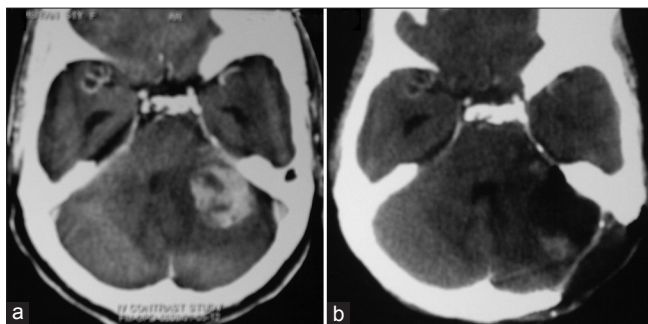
Contrast computed tomographic scan of head showing an ill-defined heterogeneously enhancing left CPA mass with mild perifocal edema (a). Second day postoperative image demonstrates the craniectomy site, adequate decompression of left CPA region with no hemorrhage on the tumor bed (b)
